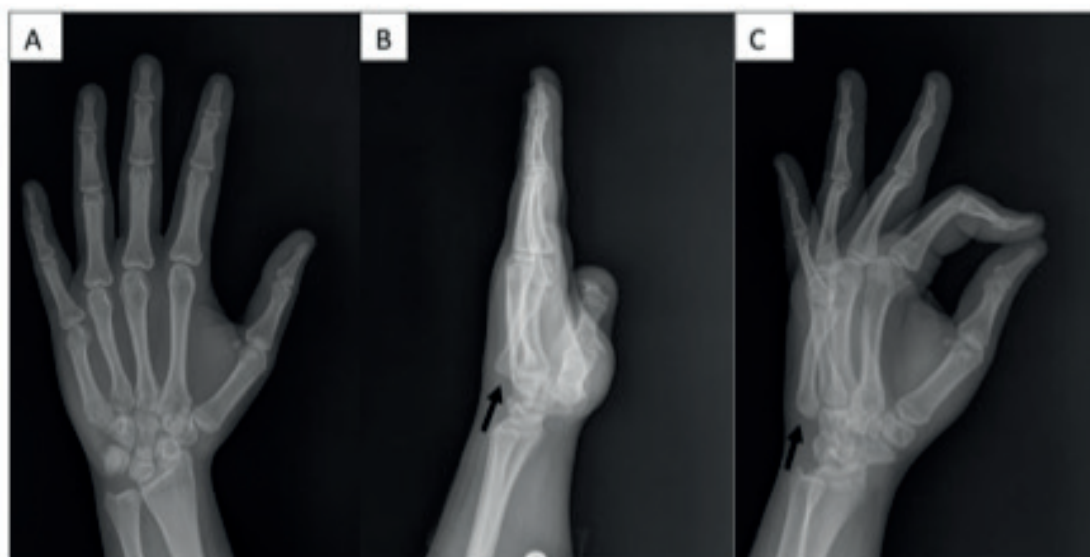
A) AP, B) lateral, and C) oblique radiographs of the second arrival at the hospital, arrow; fracture-dislocation of the 5th CMC joint.
